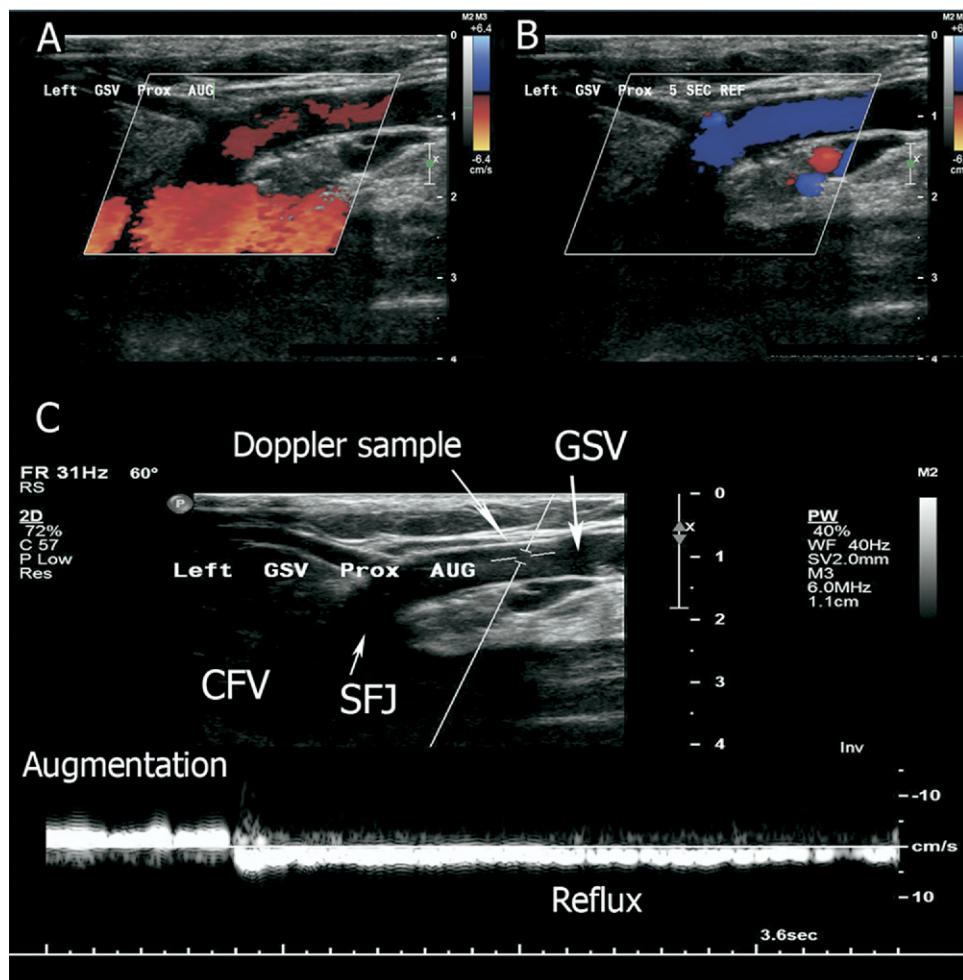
Color Doppler with calf augmentation (A), color Doppler with reflux (B), and pulsed-wave Doppler (C) of the left SFJ region. (A) Demonstrates expected antegrade flow at the SFJ region (red color) with augmentation. (B) shows opposite flow denoted by blue (reflux) in the GSV after the augmentation has stopped. (C) shows interrogation of the GSV with augmentation (white flow above the baseline) and reflux (white flow below baseline).
